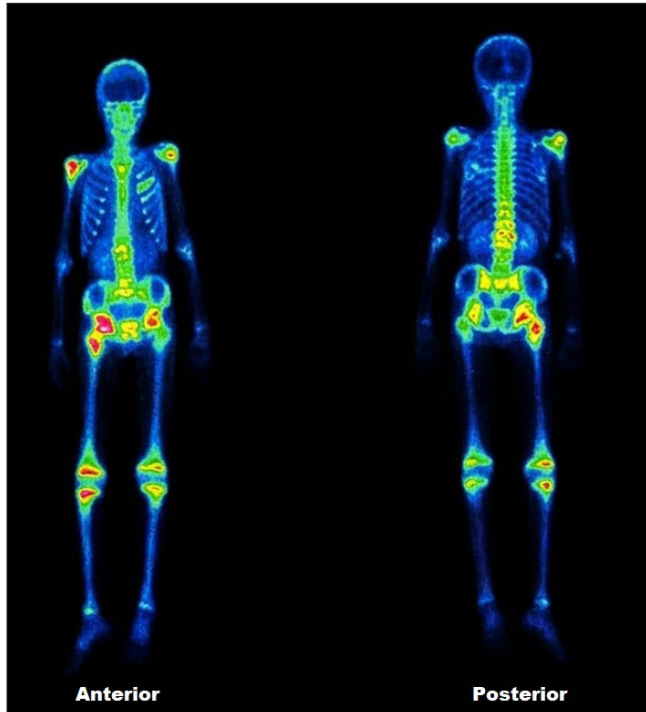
Technetium-99m bone scintigraphy (Anterior and Posterior views) showing multiple sites of pathological hyperfixation in the axial and peripheral skeleton.
